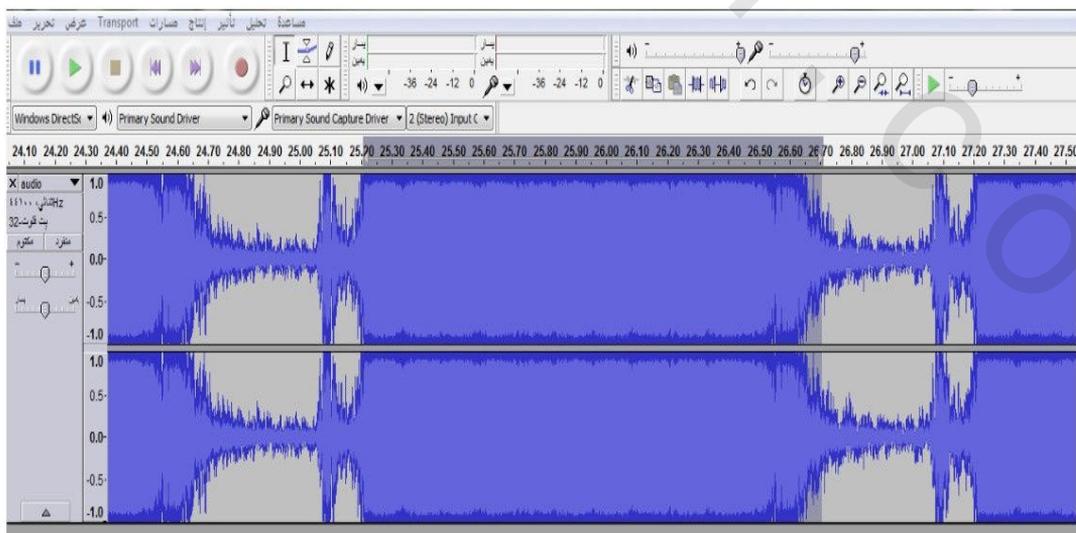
Expanded MRI sound.
